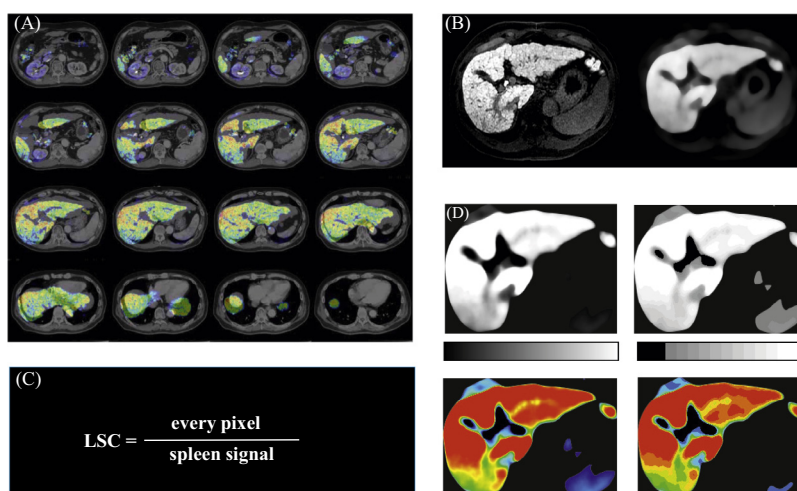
Protocol for generating functional liver maps based on planning CT and gadoxetate disodium-enhanced magnetic resonance imaging (EOB-MRI). (A) Deformable registration: basal image (grayscale), planning CT; overlaid color image, EOB-MRI. (B) Median filtering: (left) prefiltering EOB-MRI; (right) postfiltering EOB-MRI. (C) Liver-spleen contrast ratio conversion; EOB-MRI pixels divided by the spleen's signal intensity. (D) Posterization: EOB-MRI before (upper left) and after (upper right) posterization; colored EOB-MRI before (lower left) and after (lower right) posterization.
